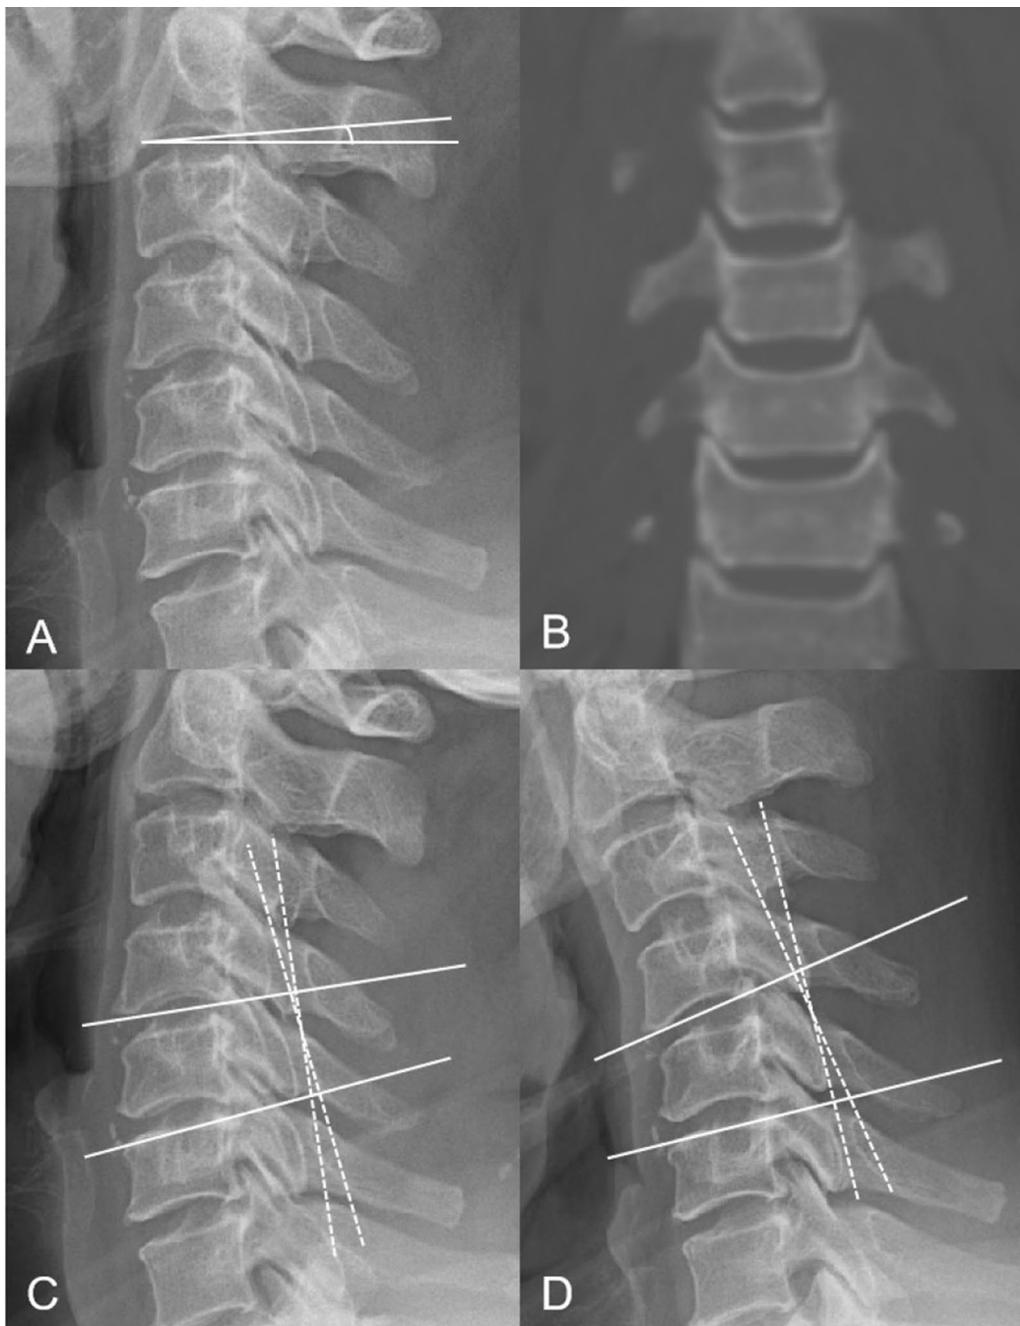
Representative preoperative images of case with pseudarthrosis. Radiographic parameters of the case presented in Fig. 3B. A Preoperative C2S was 6.5°, B the UVJ degeneration grade was 6 (C4-5 left: Grade 1; C4-5 right: Grade 1; C5-6 left: Grade 2; C5-6 right: Grade 2) and C–D segment ROM was 20.6°
